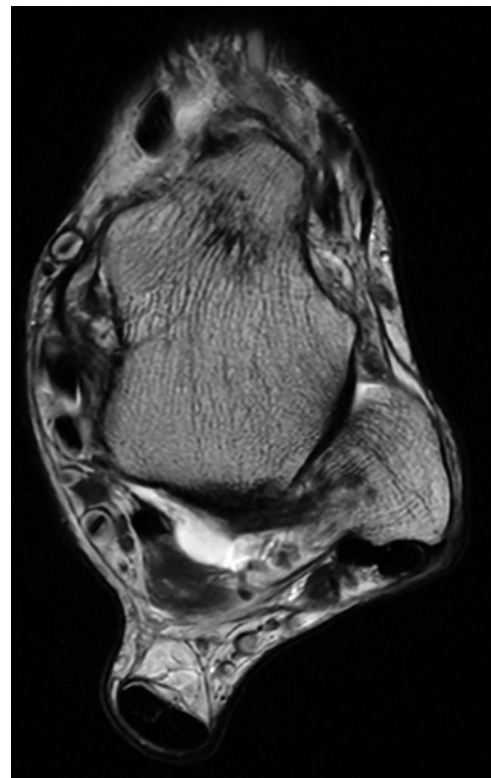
Five-year follow-up magnetic resonance imaging (T2 transverse view) showing no thickening or fluid accumulation of the extensor hallucis longus tendon.
